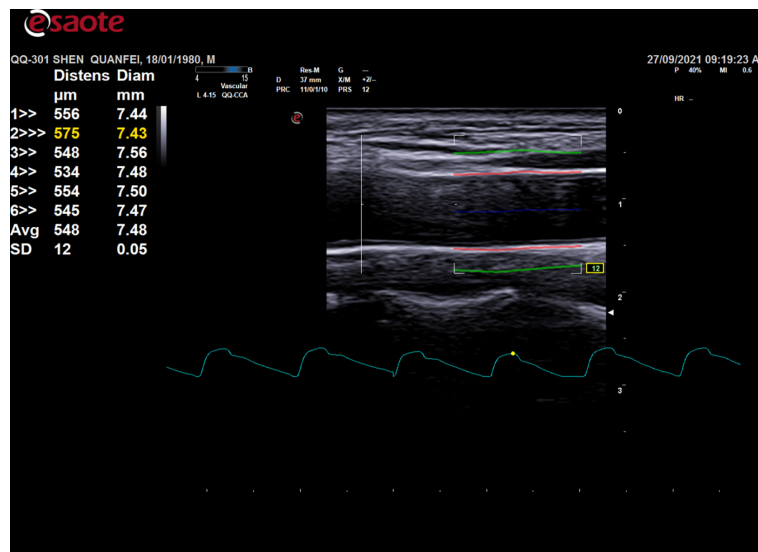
Ultrasonic image of various elastic parameters of the carotid artery detected by QAS technique (—: Central position of the common carotid artery; —: Outer layer of the common carotid artery;: Virtual line representing carotid artery pulsation). Abbreviations: QAS, Quantitative Artery Stiffness.
